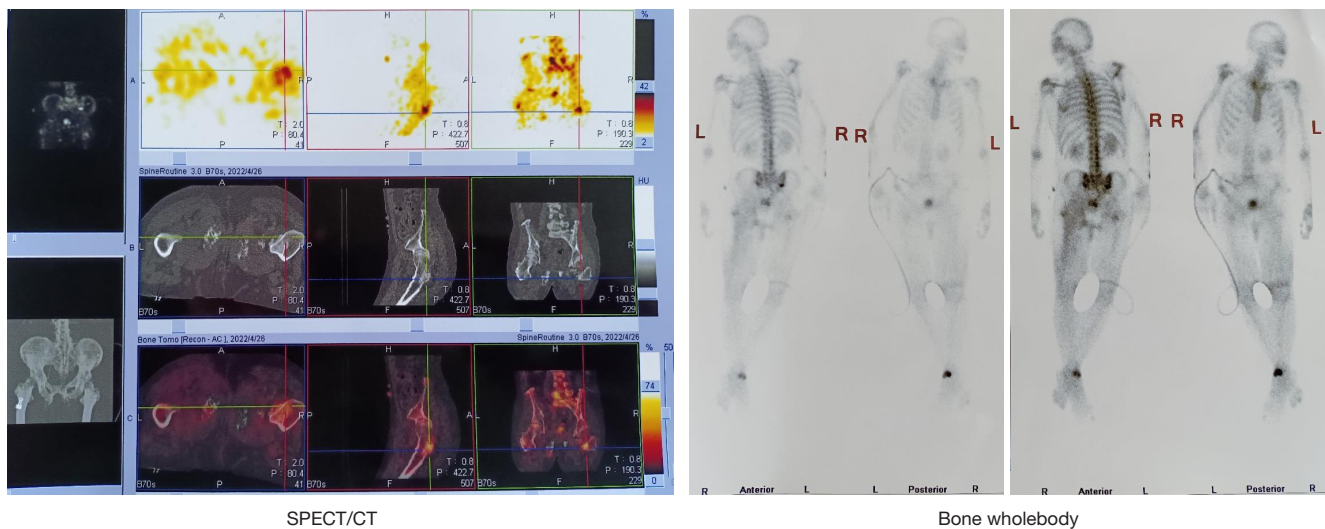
Bone metastasis (right femur, right sacroiliac joint, ischia, pubis), the patient tends to lie prone. SPECT/CT, single-photo emission computed tomography/computer tomography.
